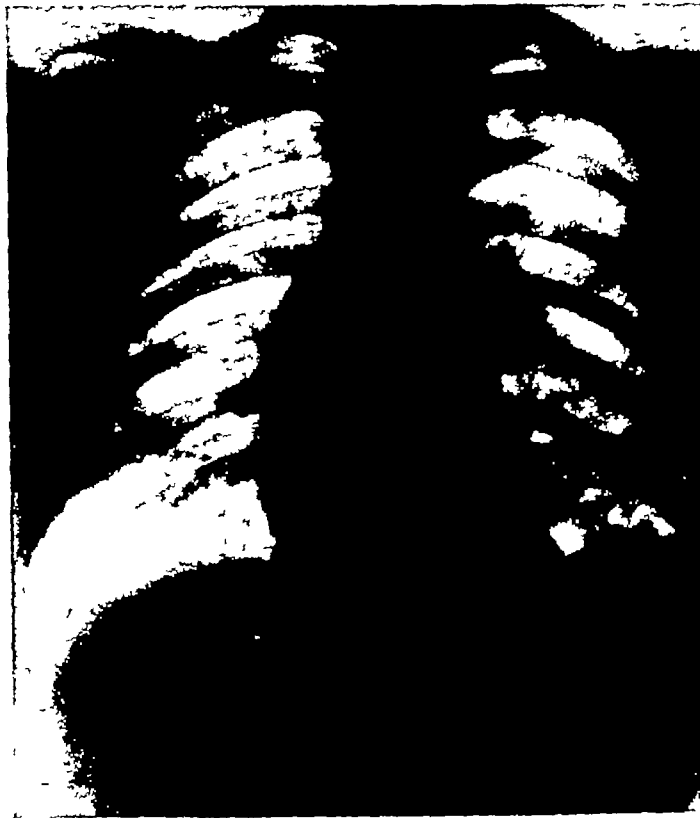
5 —Radiograph of a man of 35 years admitted with an obstructed diaphragmatic hernia (foramen of Bochdalek)
